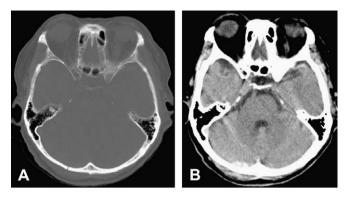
Axial CT scans on admission showing (A) a linear fracture in the occipital bone across the transverse sinus and (B) a corresponding thin epidural hematoma in the posterior fossa on the right side.
